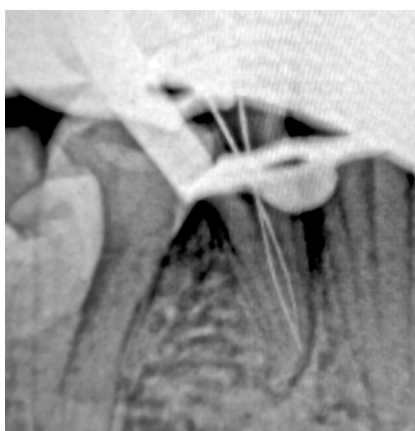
First working length radiograph
